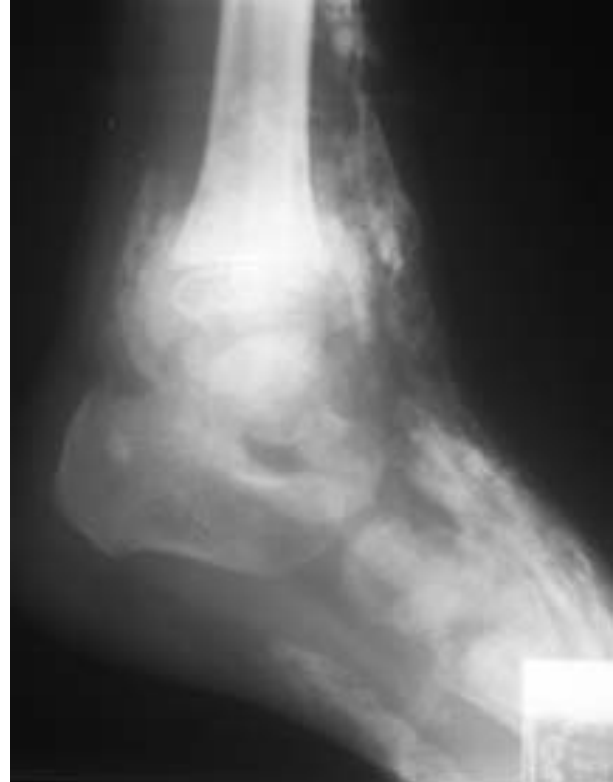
Calcinosis around ankle joint (lateral X-ray).*
